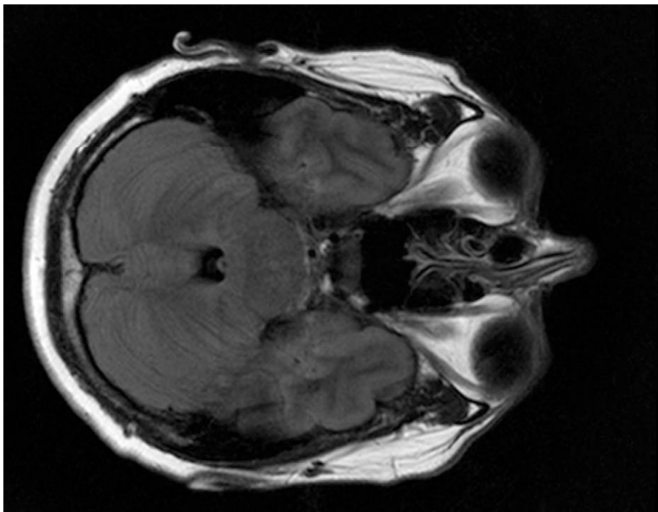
FLAIR several months after treatment, the lesion completely resolved.
